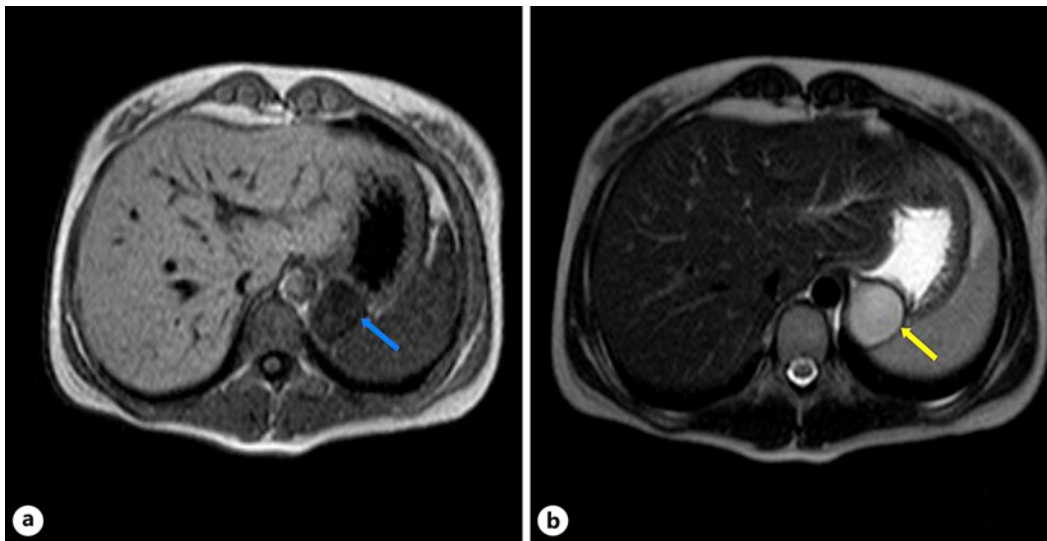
a Axial section of the upper abdomen, T1 opposed phase MRI, shows a well-defined hypointense lesion in the region of the left adrenal (blue arrow). b Axial section of the upper abdomen, T2 sequence MRI, shows a fluid signal lesion between the fundus of the stomach and spleen, in the region of the left adrenal (yellow arrow).
